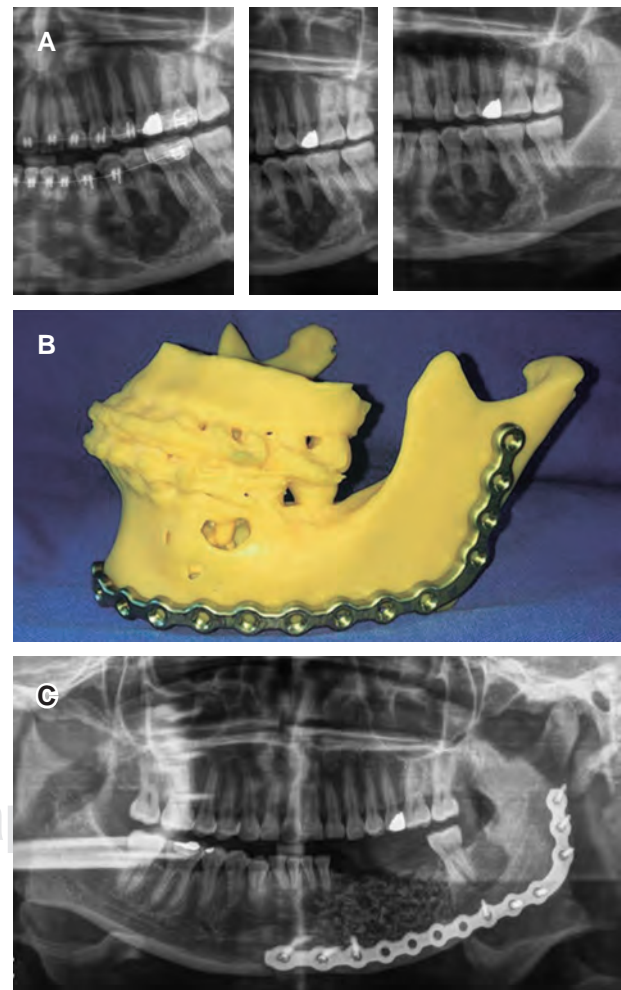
A) Initial comparative orthopantomography, one month and six weeks after infiltration with triamcinolone. B) Stereolithography used for adaptation of reconstruction plate. C) Immediate postresection and reconstruction image.
